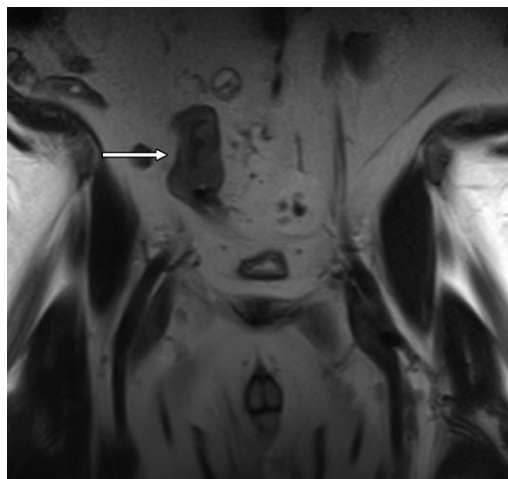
Missed synchronous colon cancer in a patient with known anal cancer. Initial coronal T2-weighted image obtained with a rectal cancer staging protocol shows the known synchronous sigmoid colon cancer (arrow), which was missed by the interpreting radiologist.
